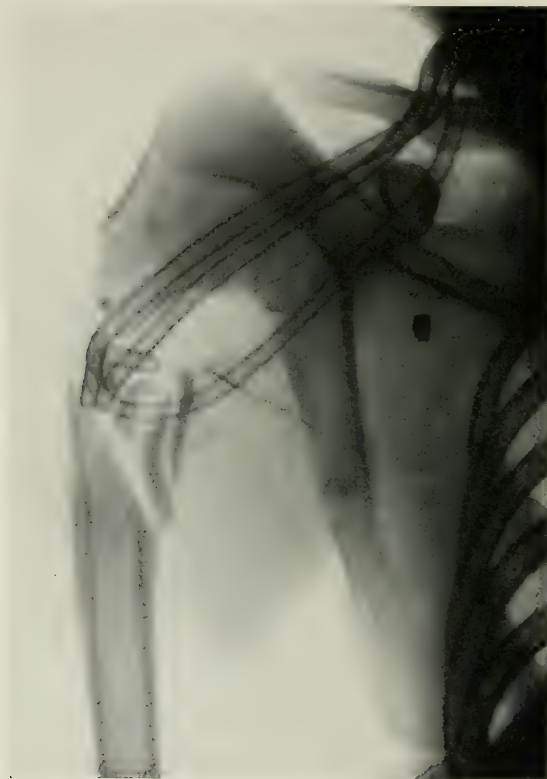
Roentgenogram Case 4 showing comminuted fracture of the surgical neck of the left humerus.
